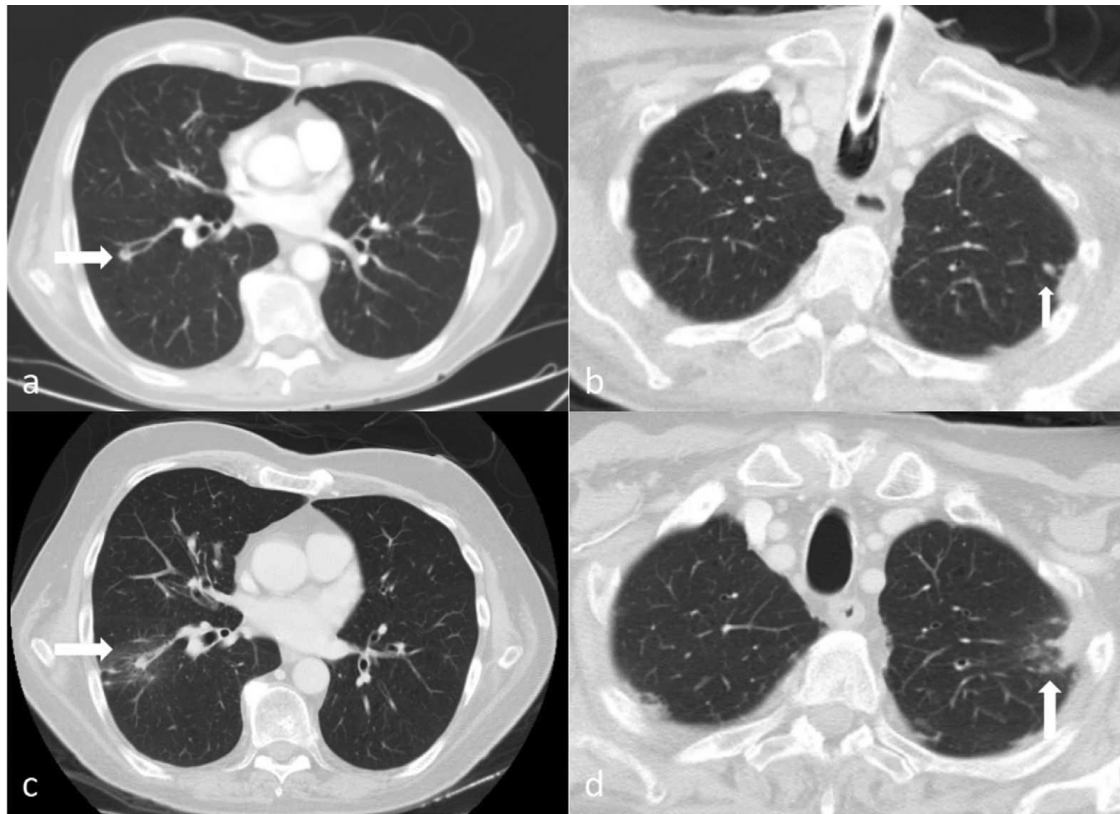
Bilateral lung metastases; axial CT images show 2 solid nodules smaller than 1 cm in the right lower lobe superior segment (A) and in left upper lobe apicoposterior segment (B) (white arrows). (C, D) Control axial CT images obtained after one year show ground glass densities around both nodules secondary to the radiotherapy treatment (white arrows).
